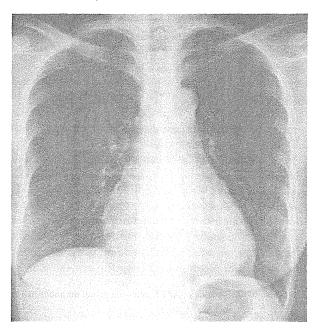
Chest X-ray obtained 2 months after discharge showing a normal cardiac shadow.
